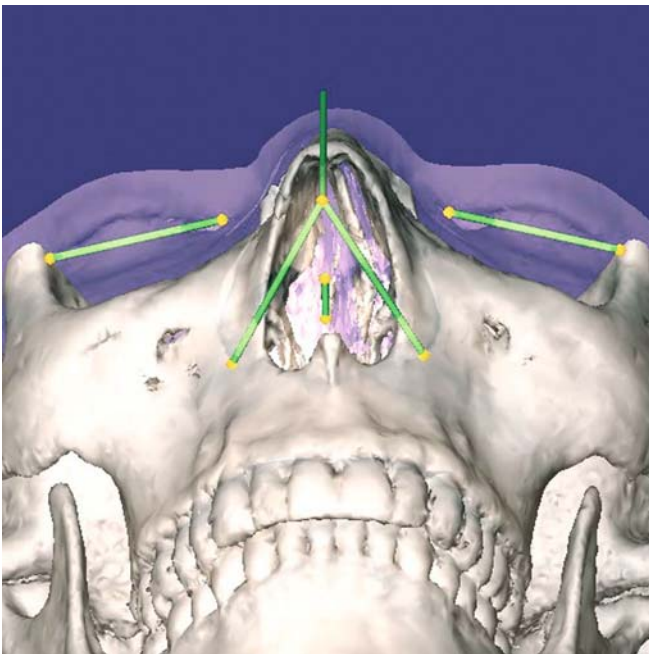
Set-up of 3-D soft tissue distances (3-D CT, hard and transparent soft tissues, patient K.C.)
